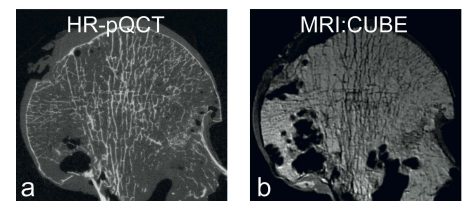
Ex-vivo images from HR-pQCT (a) and MRI with CUBE (b). Bone structures from both images are qualitatively similar. Different appearances of air inclusions are a result of different scan dates.
